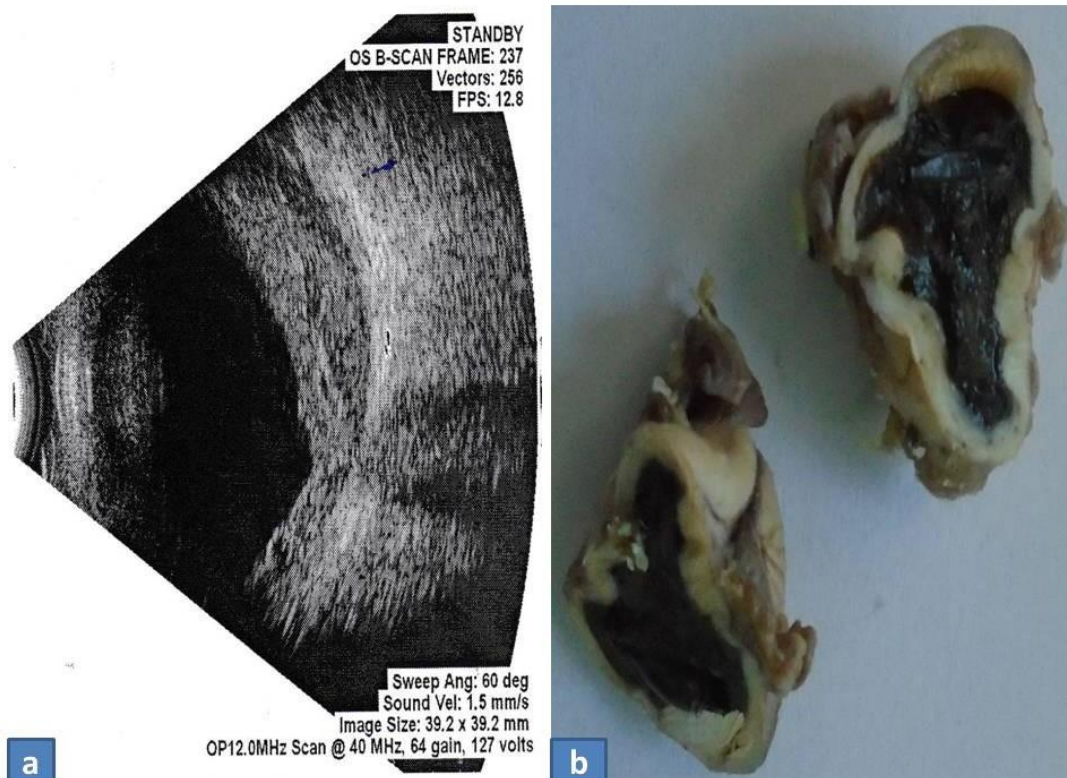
a) B-scan ultrasonography showing a marked increase in retino-choroidal thickness along with reduced axial length; b) Gross enucleated eyeball showing a small intraocular brownish mass at the posterior aspect of the eye
